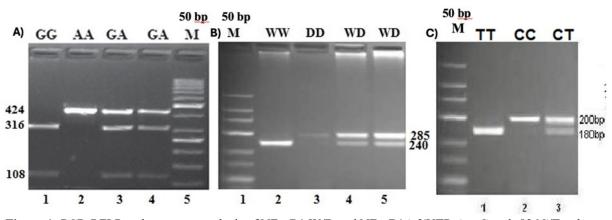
PCR-RFLP and sequence analysis of NF- κ B1 W/D and NF- κ B1A 3'UTR A \rightarrow G and -826C/T polymorphisms. A) NF- κ B1A 3'UTR A \rightarrow G polymorphism, AA genotype: 424 bp number 2, GA genotype: 424, 316 and 108 bp; numbers 3 and 4, GG genotype: 316 and 108 bp; number 1. Marker: 50 bp; B) NF- κ B1 -94W/D polymorphism, WW (ins/ins) genotype: 240 and 45 bp; number 2, WD (ins/del) genotype 285, 240 and 45 bp; numbers 4 and 5, DD (del/del) genotype 285 bp; number 3). M: 50 bp; C) NF- κ B1A -826C/T polymorphism genotypes formed after cutting with Bfa I enzyme. Sample number 1 is TT genotype (20 bp + 180 bp). Sample number 3 CT genotype (20bp+180bp+200bp). Marker: 50 bp.
